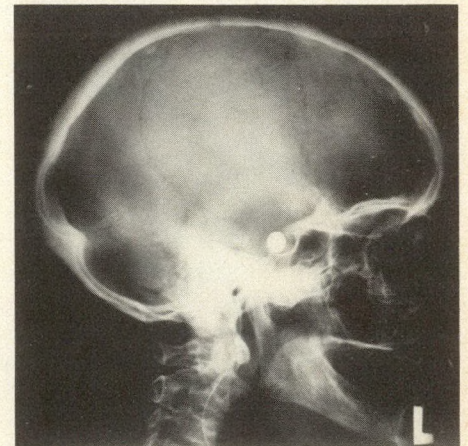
Lateral skull roentgenogram showing contrast-filled balloon in place.
